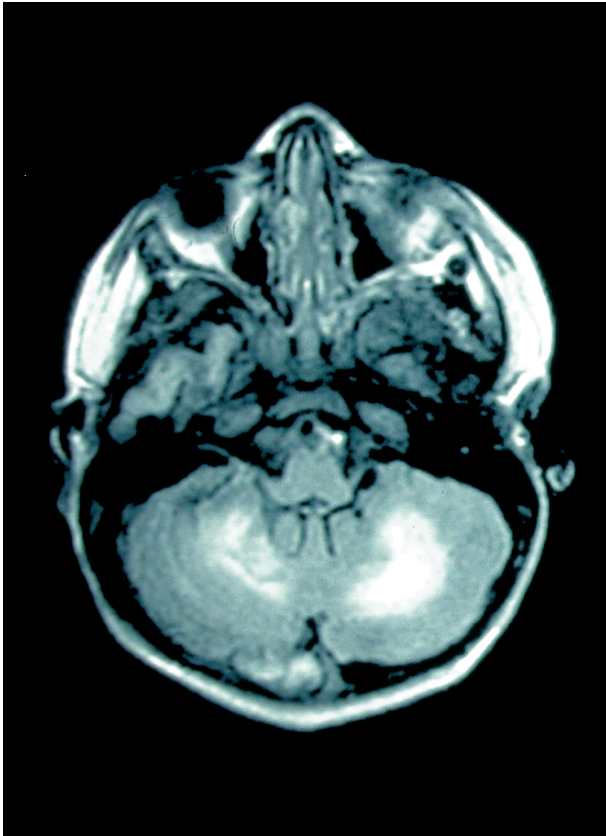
Baylisascaris procyonis* neural larva migrans in a 2.5-year-old boy who presented with acute fulminant eosinophilic meningoencephalitis. Axial fluid-attenuated inversion recovery MRI scan at the level of the posterior fossa demonstrates an abnormal hyperintense signal of cerebellar white matter.
